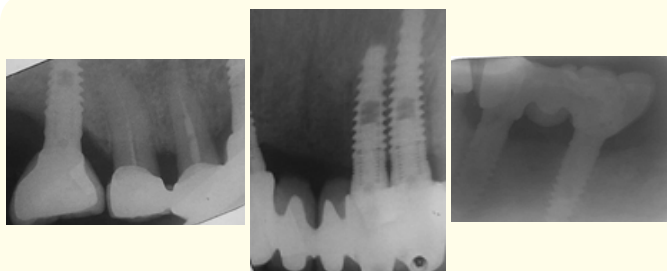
Post operative 3-6 months radiography.
